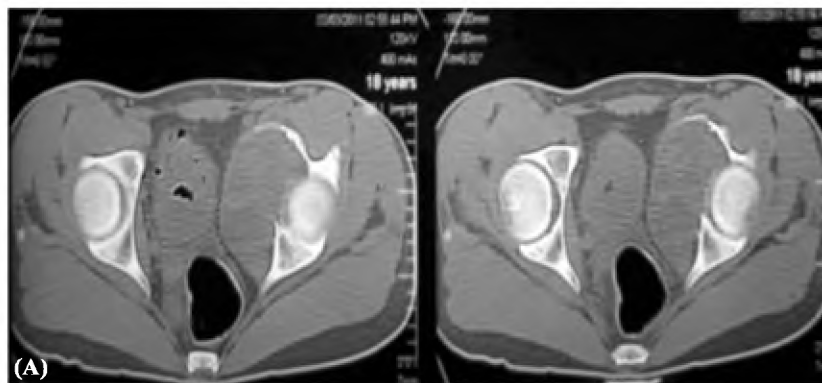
(Same patient in Fig.7) (A) Initial CT scan of the pelvis showing the lesion eroding the acetabulum (B-C) Follow-up CT after 7 months showing evident ossification of the lesion & bone formation.
